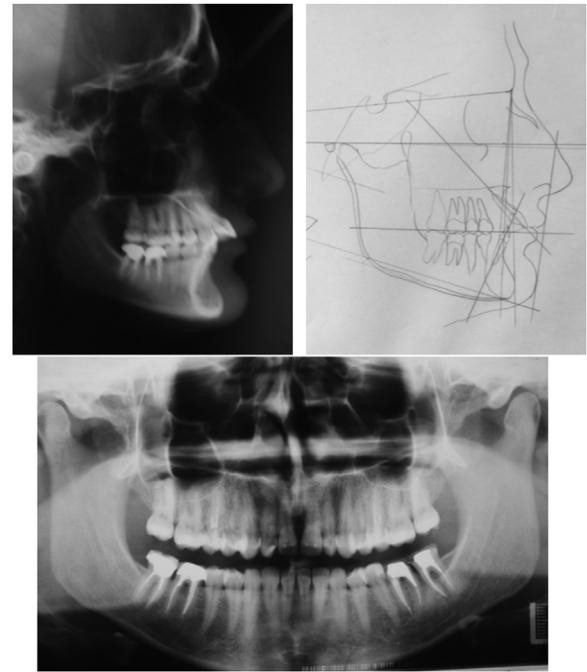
Patient 3. Pretreatment lateral cephalometric radiograph, tracing and panoramic radiograph.
